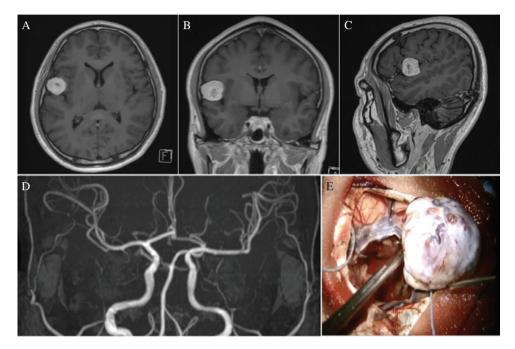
Post-gadolinium axial (A), coronal, (B) and sagittal (C) magnetic resonance imaging demonstrating homogenous enhancement of the lesion. MR angiogram (D) showing no supply from middle meningeal artery. Intraoperative picture (E) demonstrating en bloc removal of the tumor.
